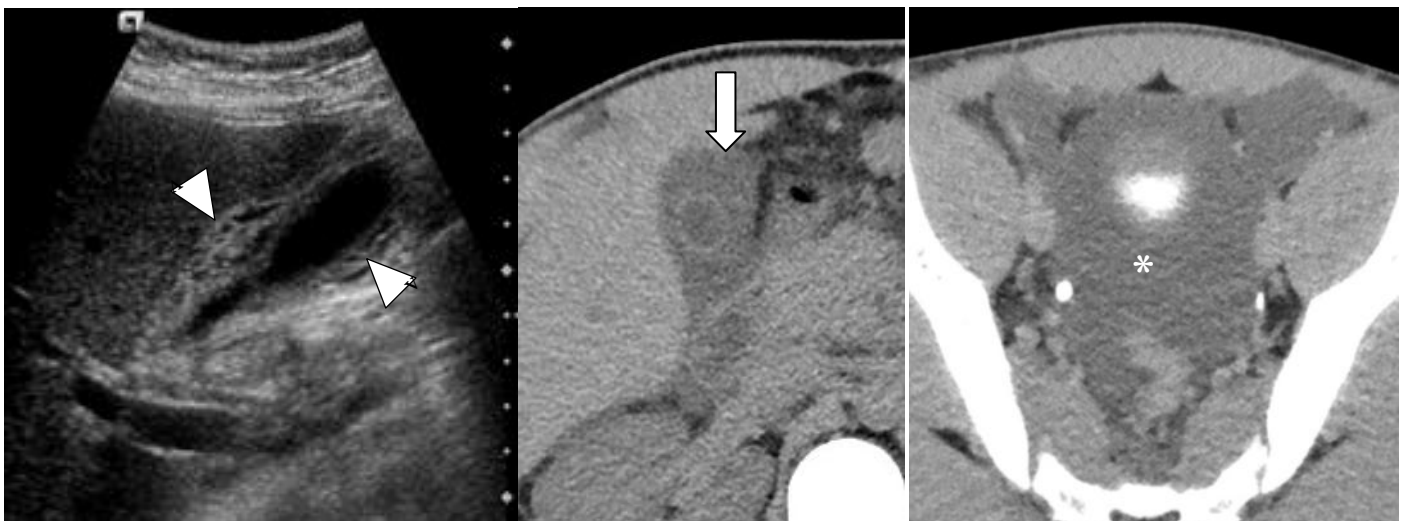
A, A 12-year old female with dengue fever complaining of abdominal pain. Ultrasonography reveals a 7 mm thick and oedematous gallbladder wall (arrowheads). B-C, CT scan of a 15-year old male also with dengue fever showing gallbladder wall oedema (arrow) and pelvic ascites (asterisk).
